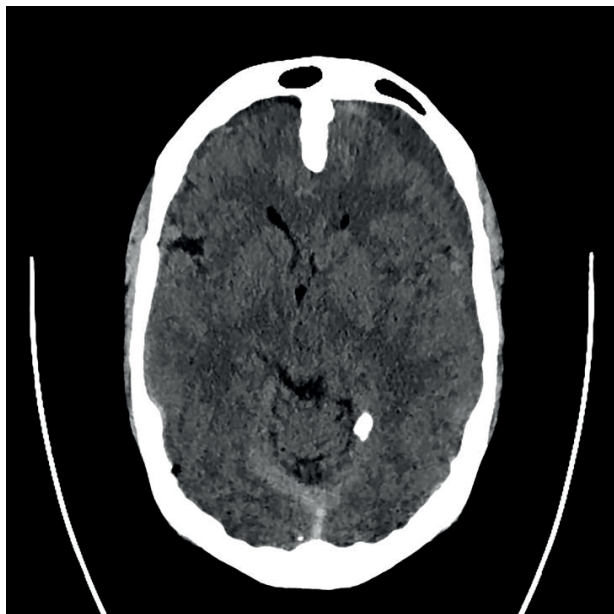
Cranial CT scan.
